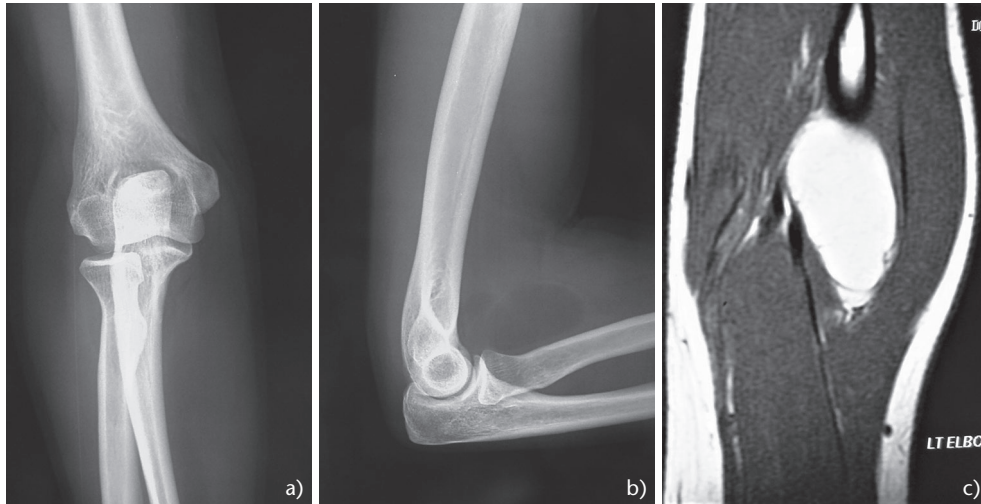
Forty-five-year-old female complaining of a painless mass at the front of the elbow area which proved to be an intramuscular lipoma. (AB) Anteroposterior and lateral radiograph of the elbow demonstrating a well circumscribed mass at the anterior surface of the elbow. (C) Magnetic resonance imaging contrast-enhanced sagittal T1 sequences of the mass measuring 4.5 x 2.7 cm.
